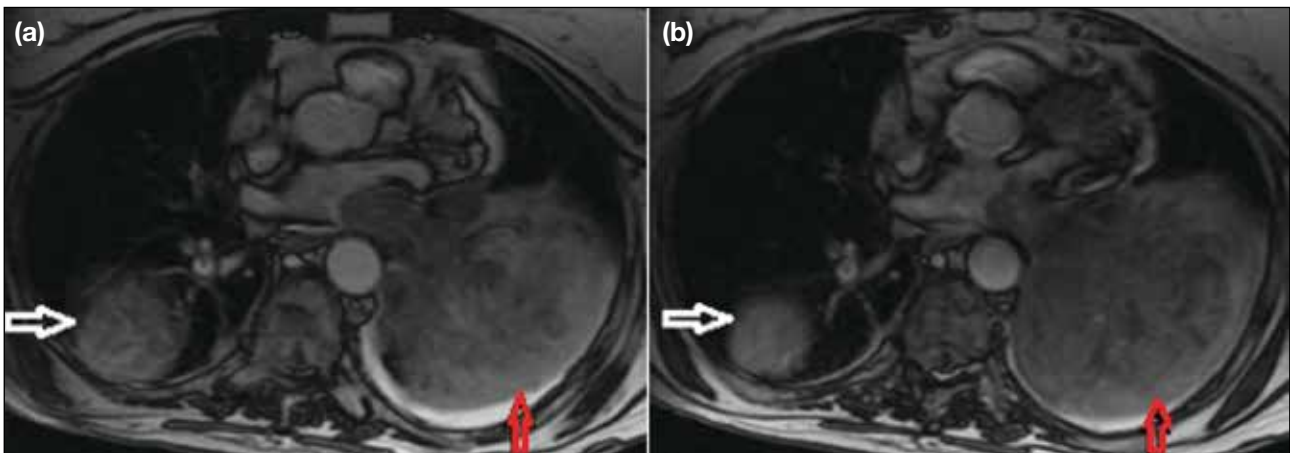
Cardiac magnetic resonance images of a 63-year-old female patient with a 2-year history of metastatic melanoma, which are sequential slices that clearly and continuously demonstrate the invasion of the mass. Metastatic masses in the right (white arrows) and left lung (red arrows) were seen. The mass in the left lung caused invasion of the left pulmonary vein leading to involvement of the left atrium.
